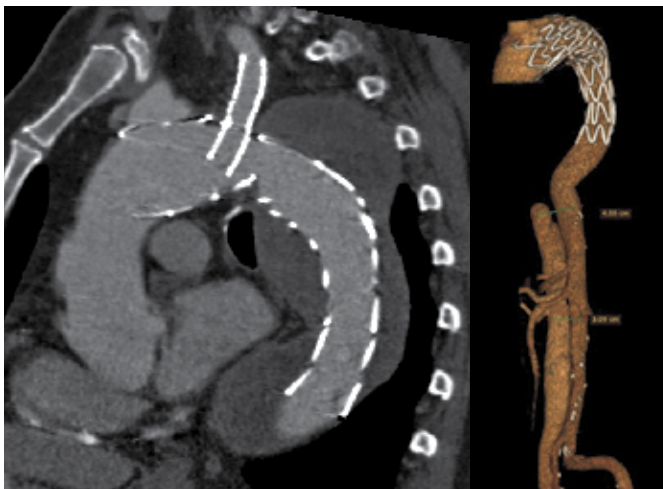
CTA 1 month post-TEVAR showing no endoleaks and complete thrombosis of the false lumen down to the level of the 11th thoracic vertebra.
